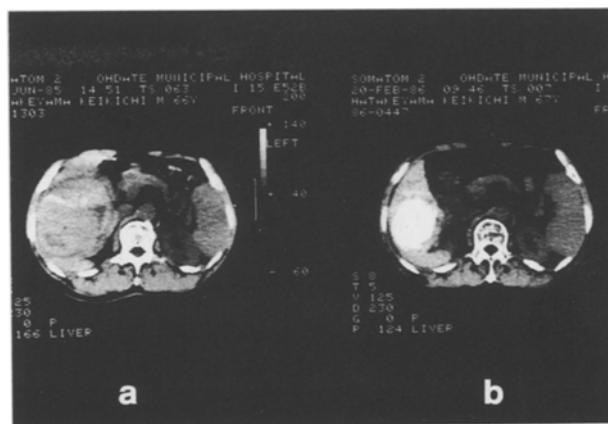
Before and after the TAE CT of a 60-year-old male patient with hepatocellular carcinoma. a An iso-density tumor can be seen on the left-side CT before TAE therapy. b A dense accumulation of lipiodol can be seen on the right-side CT after TAE therapy, and the tumor has regressed well
